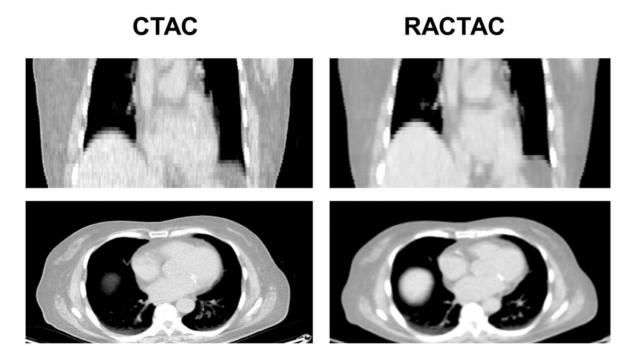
Standard attenuation map-CTAC (left) vs respiratory average CT attenuation maps-RACTAC (right). Coronal (top) and transverse (bottom) images.
